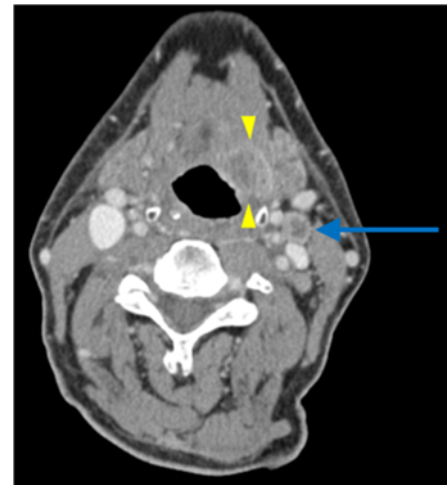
Axial CT of the neck with contrast shows an ulcerative lesion at the left tongue base (yellow arrowheads) with a pathologic necrotic level 2A lymph node (arrow). Image courtesy of the University of Massachusetts Medical School, Department of Radiology.
